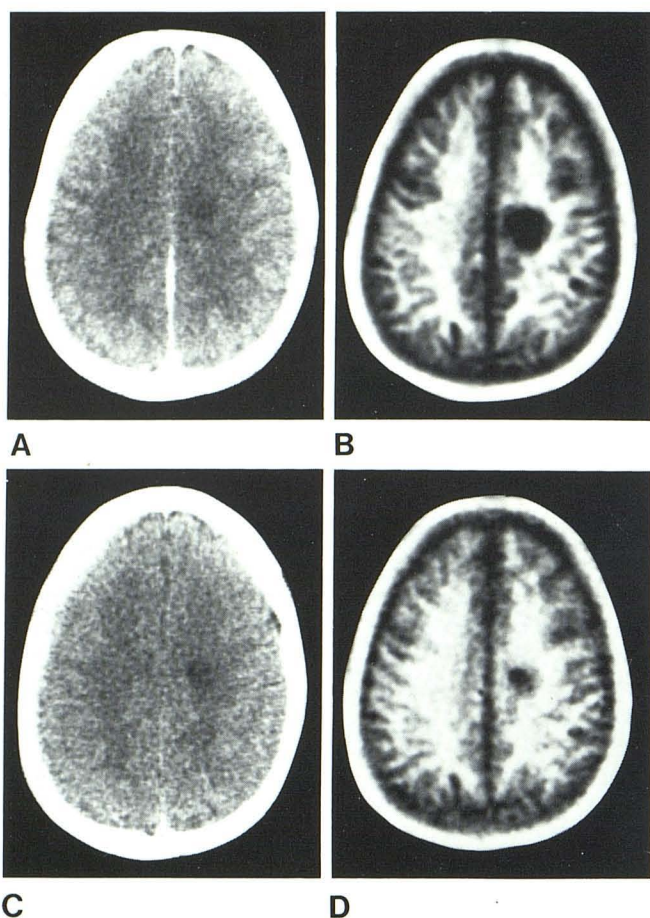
Acute multiple sclerosis. A, Initial contrast enhanced CT. B, IR_{1400/400}. Low attenuation area on CT scan (A) corresponds in position to lesion seen on NMR scan. (B). C, Follow-up CT. D, IR_{1400/400}. Lesion has diminished.
